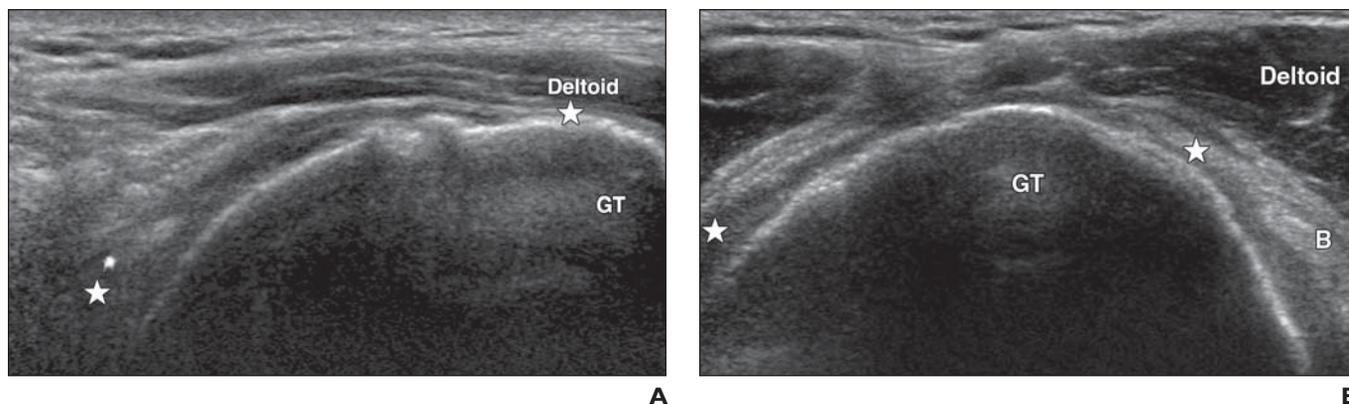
61-year-old man with asymptomatic full-thickness supraspinatus tear. A and B, Long-axis (A) and short-axis (B) ultrasound images in expected location of supraspinatus tendon show complete full-thickness tear of supraspinatus tendon (between stars). GT = greater tuberosity, B = tendon of long head of biceps brachii muscle.
